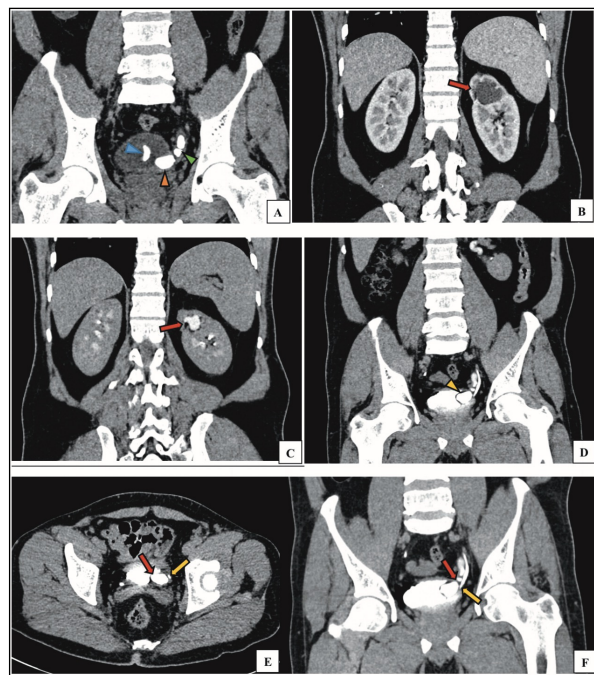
(A-F): CT urography images. Coronal reformatted non-contrast (A), corticomedullary phase (B), and excretory phase images (C, D and F), and axial excretory phase (E) CT urography images show normal contrast uptake (B) and excretion (C) in bilateral kidney. The left kidney shows a complete duplex system with hydronephrosis of left upper pole moiety (red arrows). The left upper pole moiety shows a ureterocele with a calculus noted within it. Few smaller calculi are also seen in the distal aspect of left upper pole ureter (green arrow head in A). Delayed (E and F) images show the anomalous relation of the upper (red arrows) and lower (yellow arrows) pole moieties with the lower pole moiety seen opening anterior (E) and inferior (F) to the upper pole moiety.
